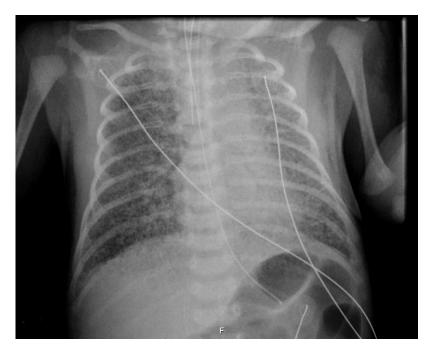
X-ray of diffuse congenital lymphangiectasia (clinical case number 4).
